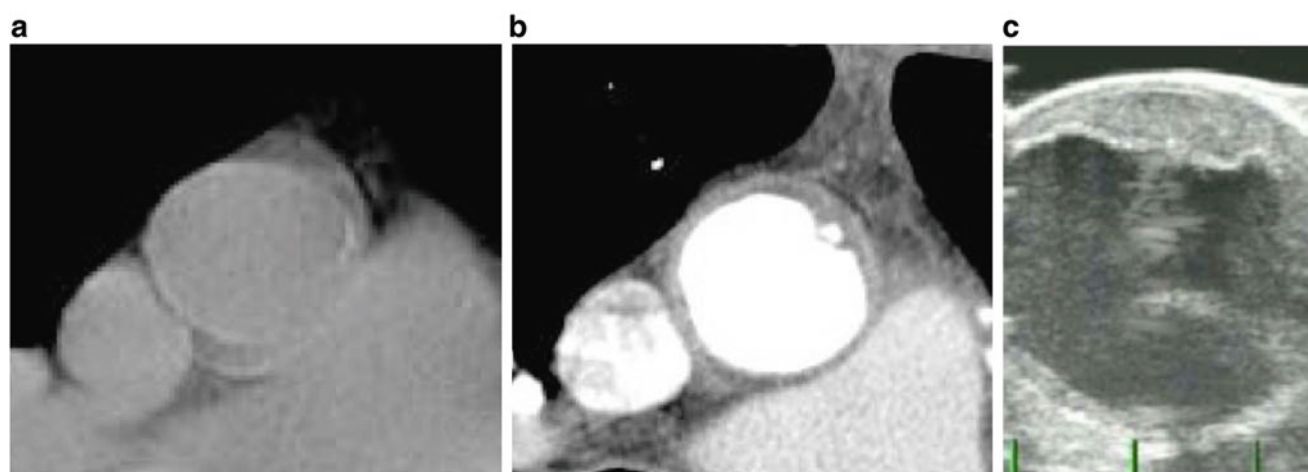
Sample images of the ascending aorta. (a) is a simple CT image, (b) shows contrast-enhanced CT, and (c) shows epiaortic ultrasound echography image
